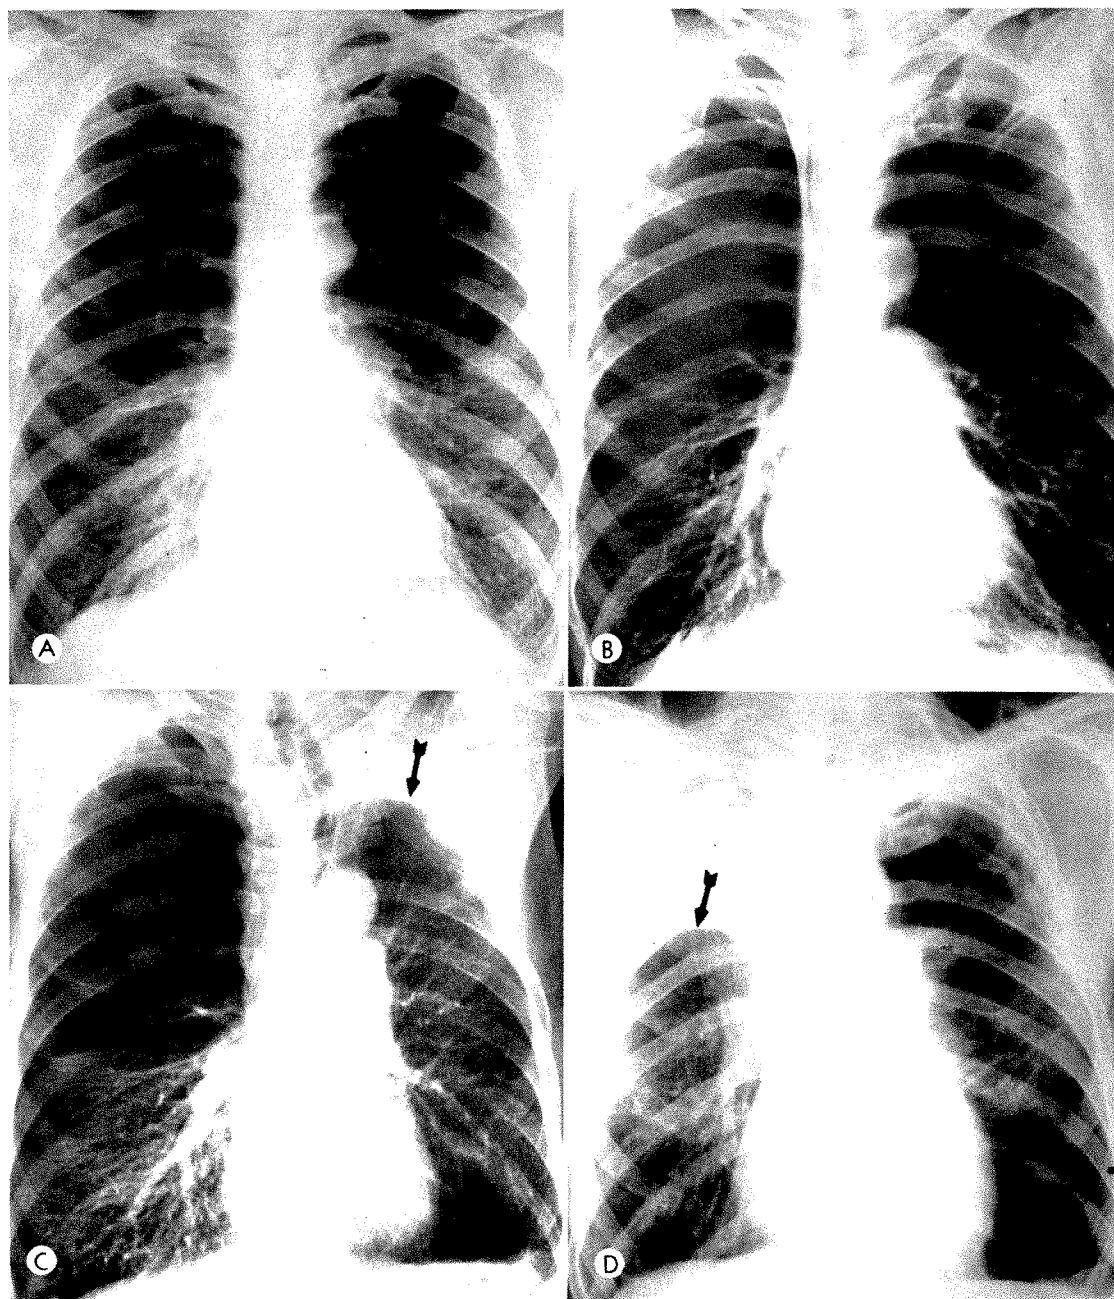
Case IV. *Bullous emphysema improved by bilateral upper lobectomy.* (A) Conventional frontal roentgenogram shows huge bilateral bullae of both upper lung fields with compression of the lower lung fields. (B) Angiogram shows absence of pulmonary arterial circulation of the upper lobes with marked compression of the pulmonary vasculature of the lower lobes. (C) Following left upper lobectomy and formation of a pleural tent (arrow), the left pulmonary arterial tree was no longer compressed. Note the appearance of a large left lower lobe bulla. Despite this, clinical improvement resulted. (D) Four years later, recurring dyspnea necessitated a right upper lobectomy and pleural tent formation (arrow). This was followed by improvement and return to work, now of five years' duration.
